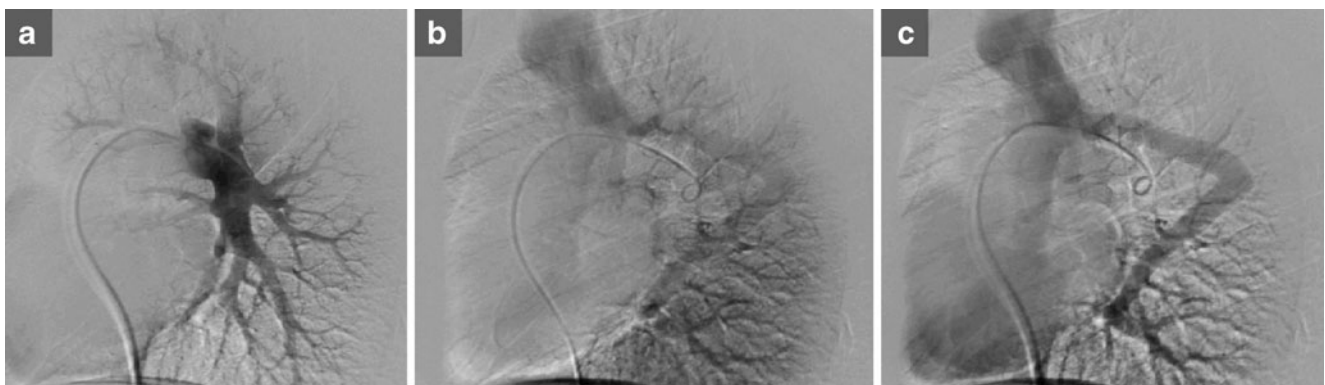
CT scan thorax: demonstrating a arterial, b capillary and c venous phases showing the abnormal vein
